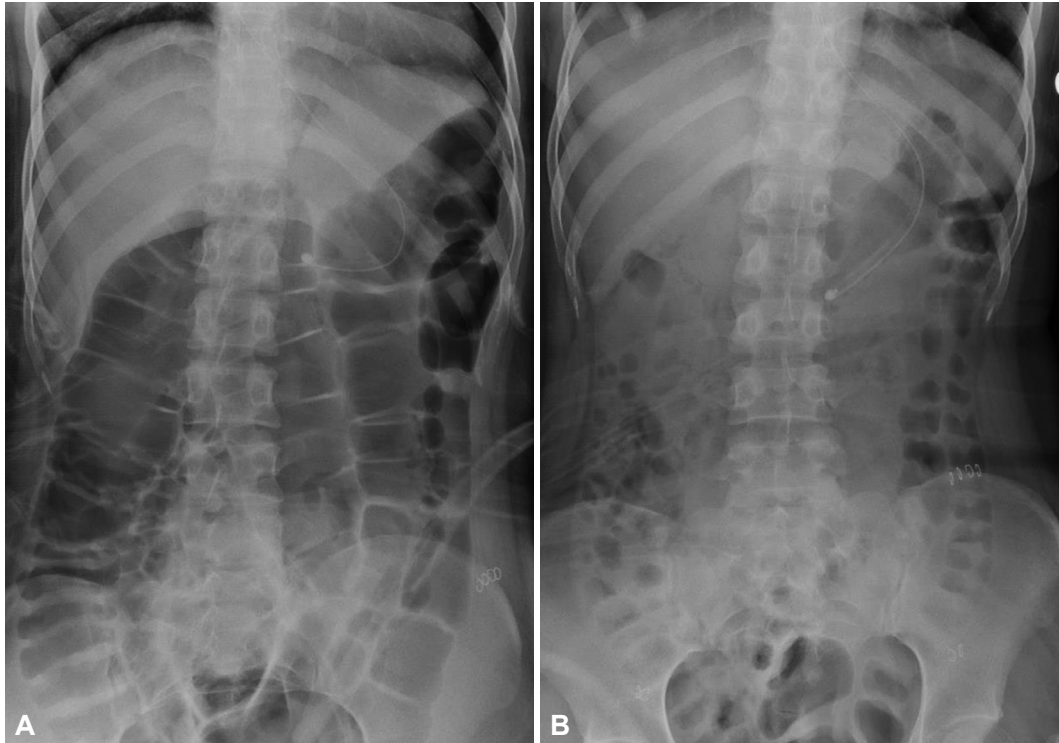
Treatment effect of neostigmine on ACPO. Plain abdominal radiographs obtained before (A) and after (B) the intravenous administration of neostigmine (2 mg) in a 23-year-old female with anti-N-methyl-D-aspartate receptor encephalitis. (A) Initial imaging shows massive colonic dilatation consistent with ACPO. (B) A bowel movement occurred 2.5 hours after the neostigmine injection, and follow-up imaging performed 24 hours after the injection showed an improvement in colonic dilatation with a decrease in the diameter of the colon. ACPO: acute colonic pseudo-obstruction.
